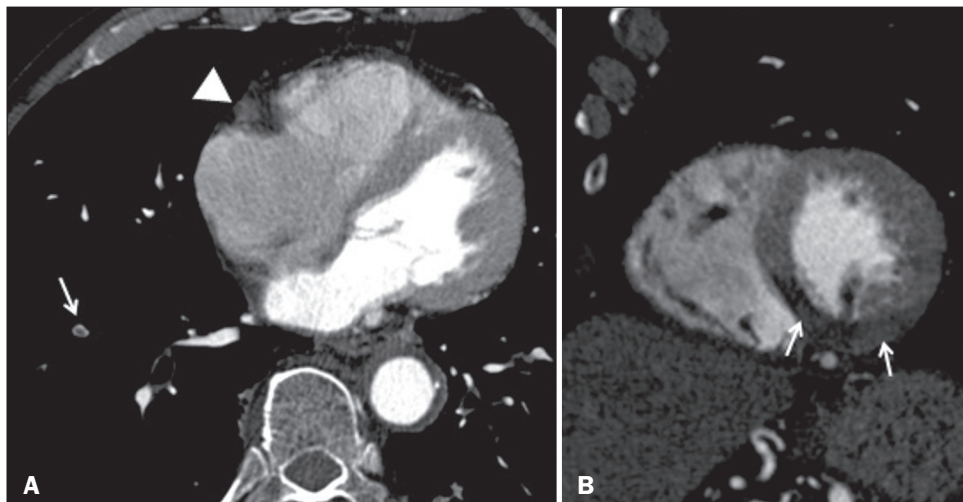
A: Axial CTA at the level of the heart, showing a lack of contrast enhancement of the right coronary artery (arrowhead) and a central filling defect in a subsegmental branch of the right pulmonary artery supplying the lower lobe (arrow), consistent with acute pulmonary embolism. B: CTA reconstruction in the short axis plane of the left ventricle, showing hypoperfusion of the inferior, inferolateral, and inferoseptal segments of the left ventricle.
